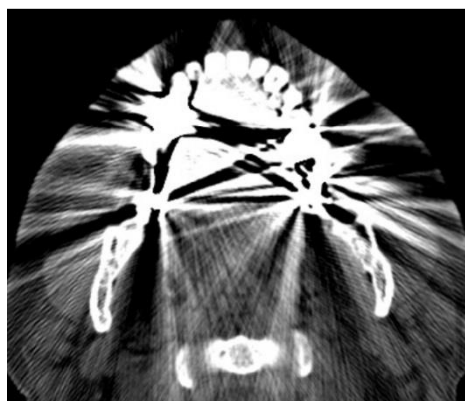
Metal artifacts in dental CT of maxilla after FBP (axial view). Anatomical structures are shadowed and distorted by the metal artifacts [46].
